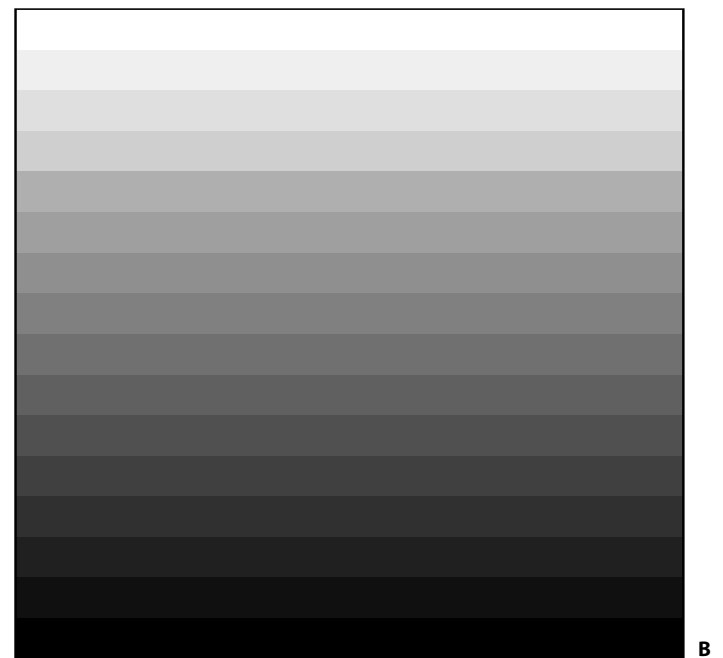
A. Radiograph performed at 90 kVp. Note the lesser contrast as compared with the radiograph in the preceding figure. B. Long-scale contrast, typical of radiographs performed at high kilovoltage.
